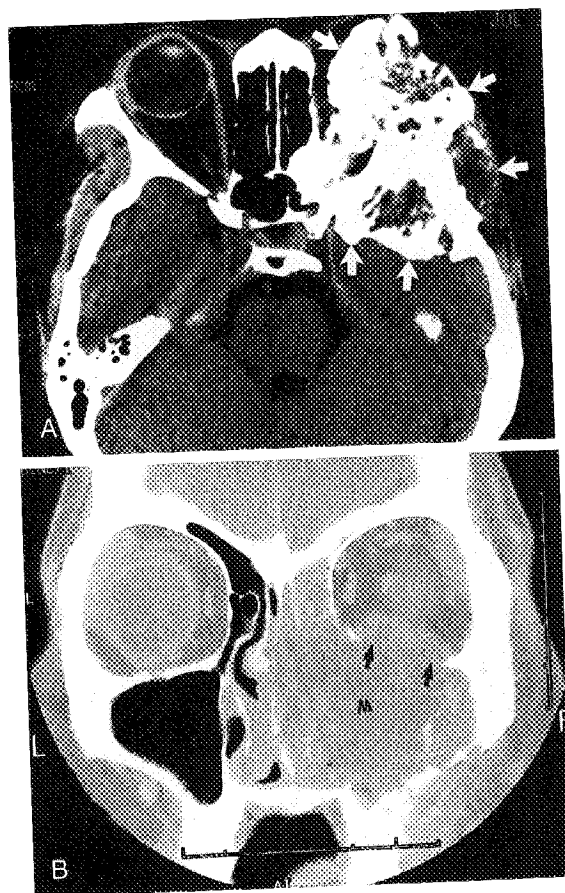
A, CT scan shows destructive mass (arrows) with marked intratumoral bone formation compatible with osteosarcoma. B, CT scan in another patient with chondrogenic osteosarcoma shows destructive mass (M) invading the floor of the orbit (arrows).
